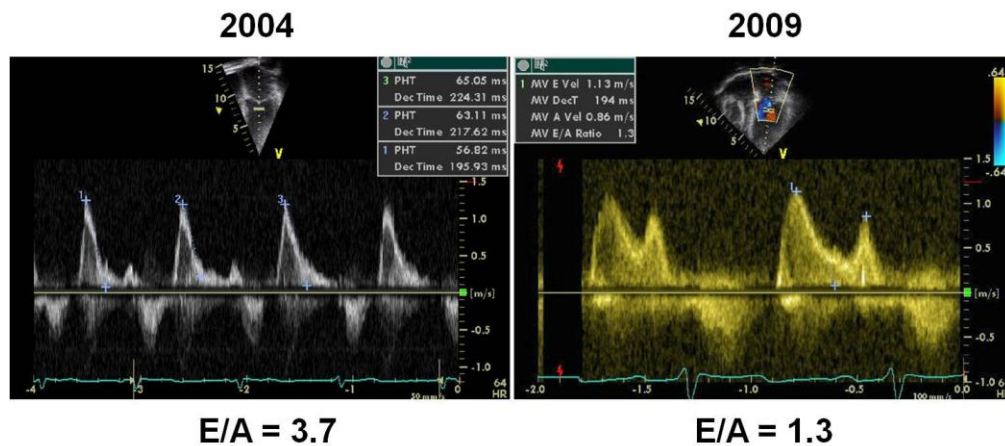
LV inflow Doppler tracings taken 5 years apart. The restrictive E/A pattern evident on the left has normalized on the right. However, mitral annular velocities are low ($E' = 5.5$ cm/sec), suggesting significantly impaired myocardial relaxation (tracing not shown). Note: heart rate is similar on both tracings, 61-64 /min, despite different recording speeds
